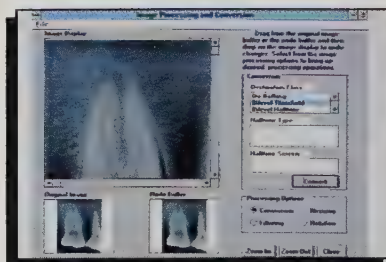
The Windows-based program permits the integration of patient information with digitized X-rays and intraoral images.
